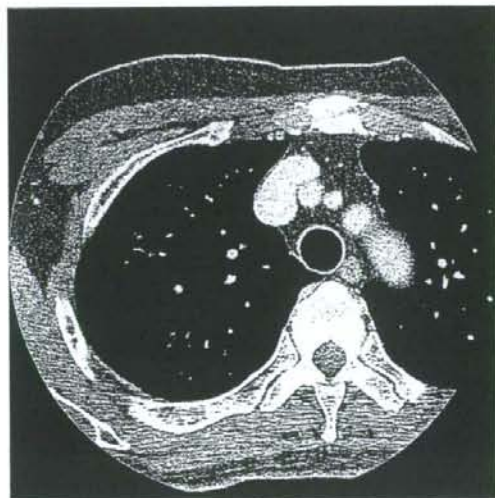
Typical presentation of a ground glass opacity lesion in the right upper lobe. This needs to be diagnosed on high-resolution (thin-slice) CT with a scanning thickness of less than 1 to 2 mm.
